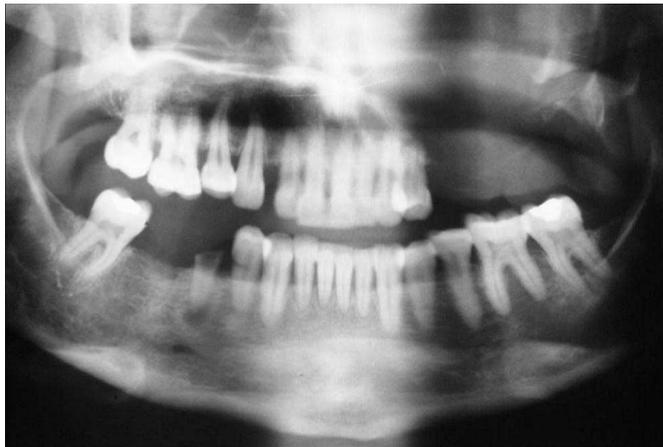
Radiographies showed the presence of a radiolucent image of irregular edges with discrete radiopaque focus in its interior.
